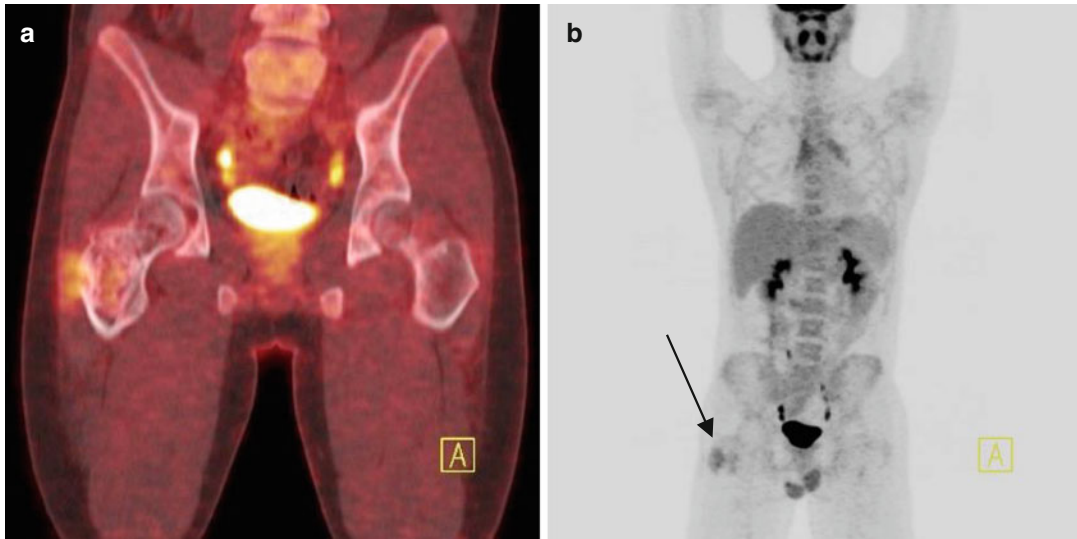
Coronal PET/CT image (a) and MIP image (b) 5 months after the end of therapy show further improvement in the region of the neck of the right femur and slightly increased FDG uptake at the adjacent soft tissue (SUV_{max} 2, 5)
